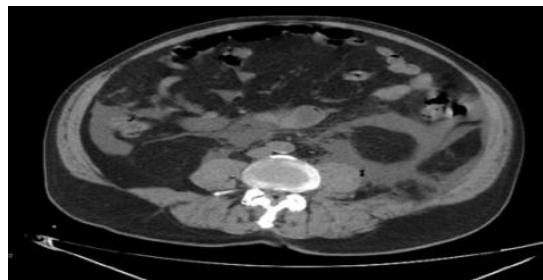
CT images - cross section with free gas: Abdomen.
